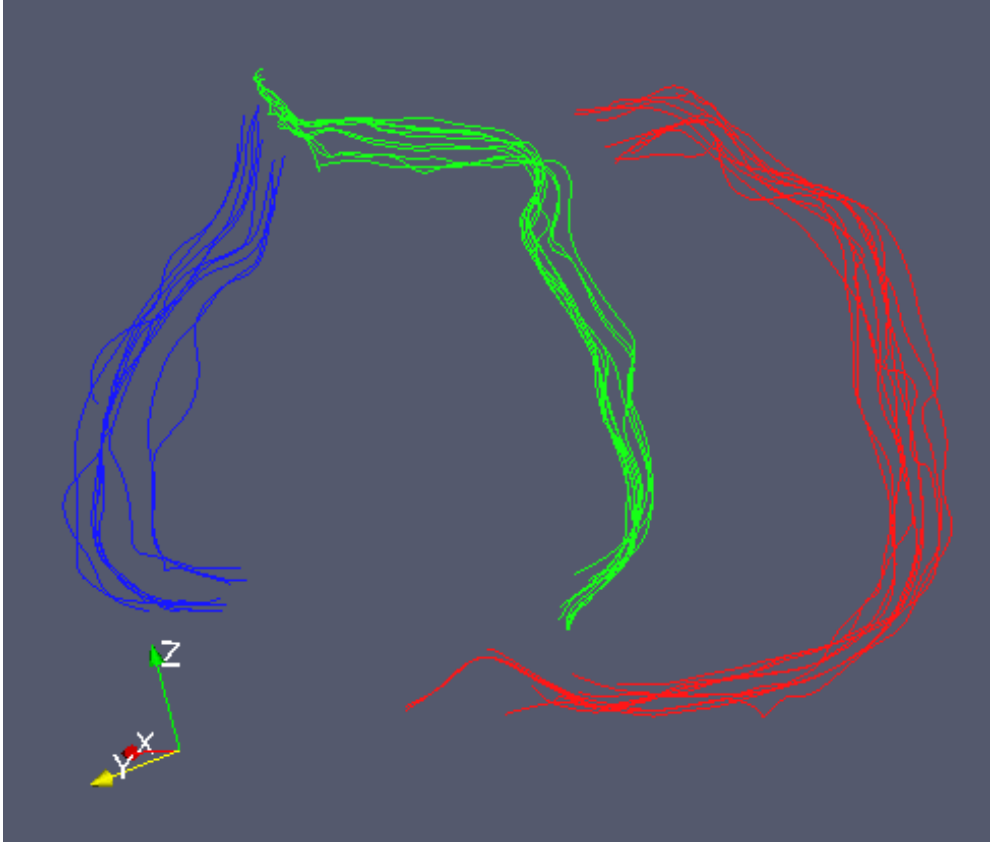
Extracted coronary artery Centrelines from 4D CTA. The red lines denote the right coronary artery, the green lines for the left anterior descending and its branches, and the blue lines for the left circumflex artery and its branches.
